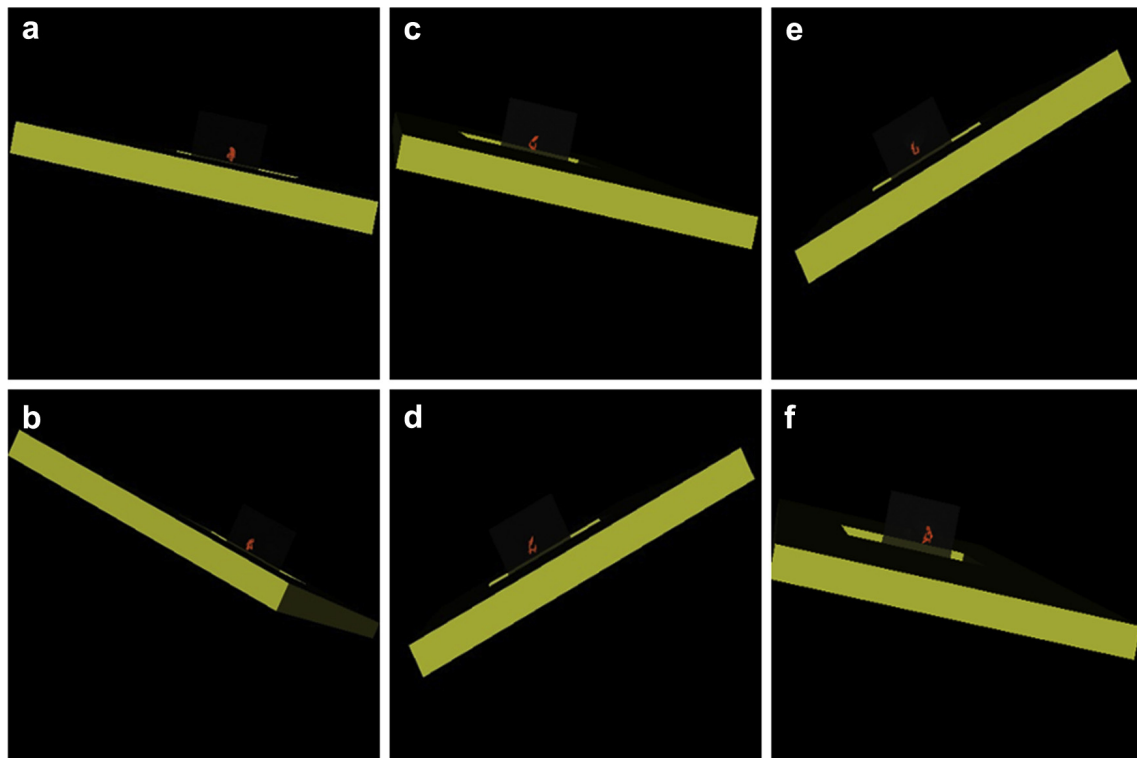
Three-dimensional reconstruction of knee effusion imaging; *red imaging* indicates knee effusion. (a) FLIPUS intervention at 2 wk; (b) Sham intervention at 2 wk; (c) FLIPUS intervention at 4 wk; (d) Sham intervention at 4 wk; (e) FLIPUS intervention at 8 wk; (f) Sham intervention at 8 wk ($n = 10$ knees each). FLIPUS = focused low-intensity pulsed ultrasound.
